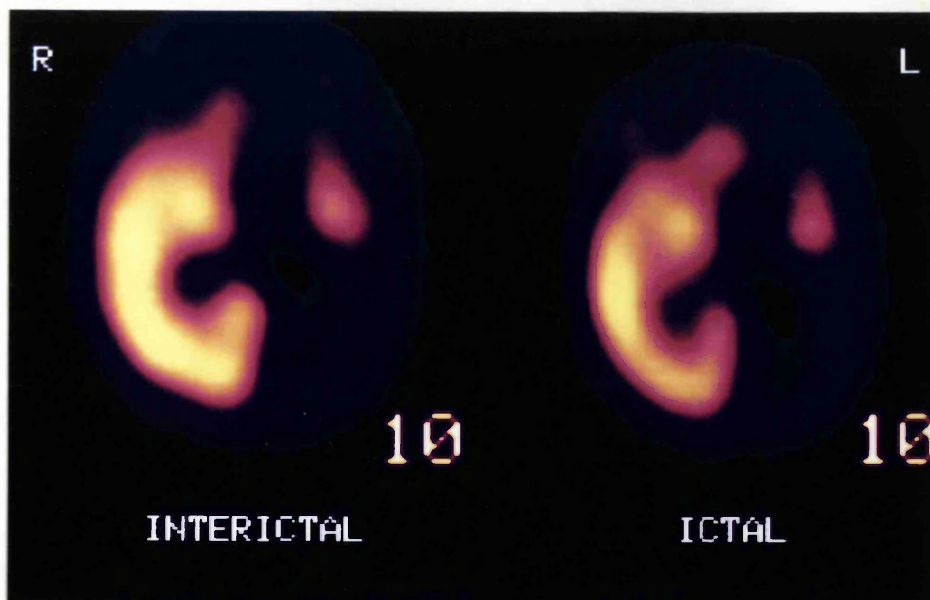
Transverse sections, MRI (reconstructed from a 3D MP-RAGE data set) parallel to the axis of the temporal lobes (A) and  $^{99}\text{Tc}^m$  HMPAO SPECT scans (B) of patient H4. MRI shows encephalomalacia of most of left hemisphere. Interictal SPECT demonstrates hypoperfusion of most of the left hemisphere; the ictal scan shows a similar picture with an additional area of hyperperfusion in the left occipital region (arrowed).
